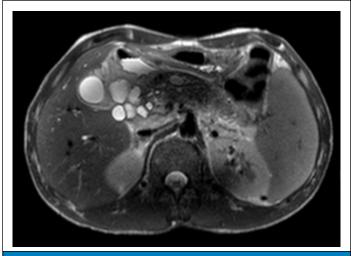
Cystic form of DD, MR image on T2 WI
